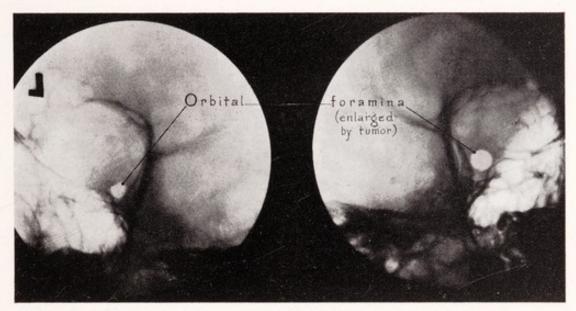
Case 29. X-rays of orbital foramina showing enlargement of foramen on side of tumor, which has extended directly through this canal.
